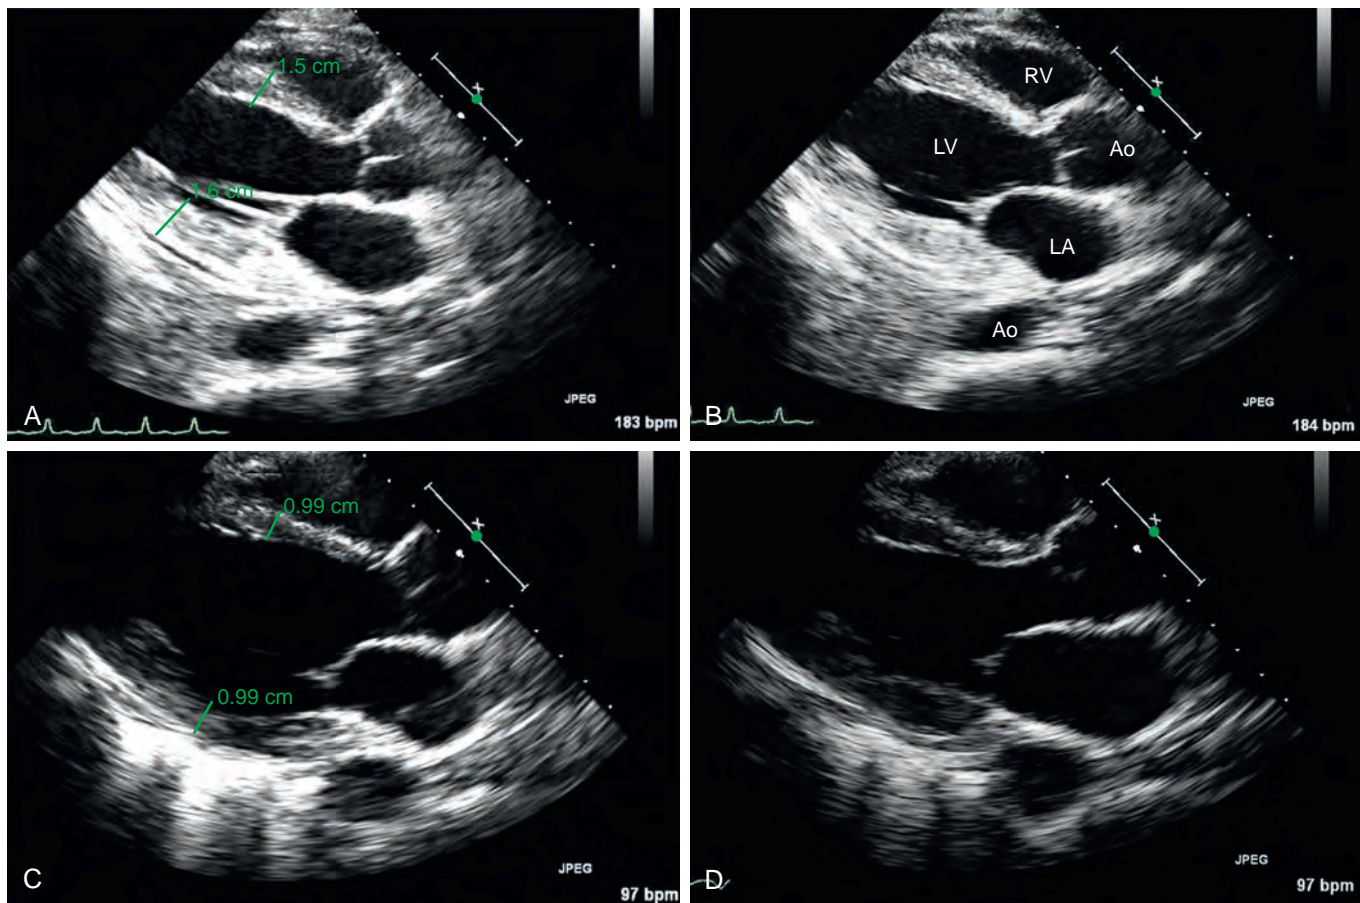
Initial imaging at presentation of a patient with fulminant myocarditis. All images are transthoracic echocardiography images of the parasternal long-axis view. (A) End-diastolic frame with severely thickened myocardium. (B) End-systolic frame of the same clip demonstrating poor systolic function with minimal change in chamber size. (C) End-diastolic frame taken 34 days later demonstrating a resolution of myocardial edema with normal wall thickness. (D) End-systolic frame demonstrating improved systolic function in the form of an improved end-systolic dimension. Ao, Aorta; LA, left atrium; LV, left ventricle; RV, right ventricle.
